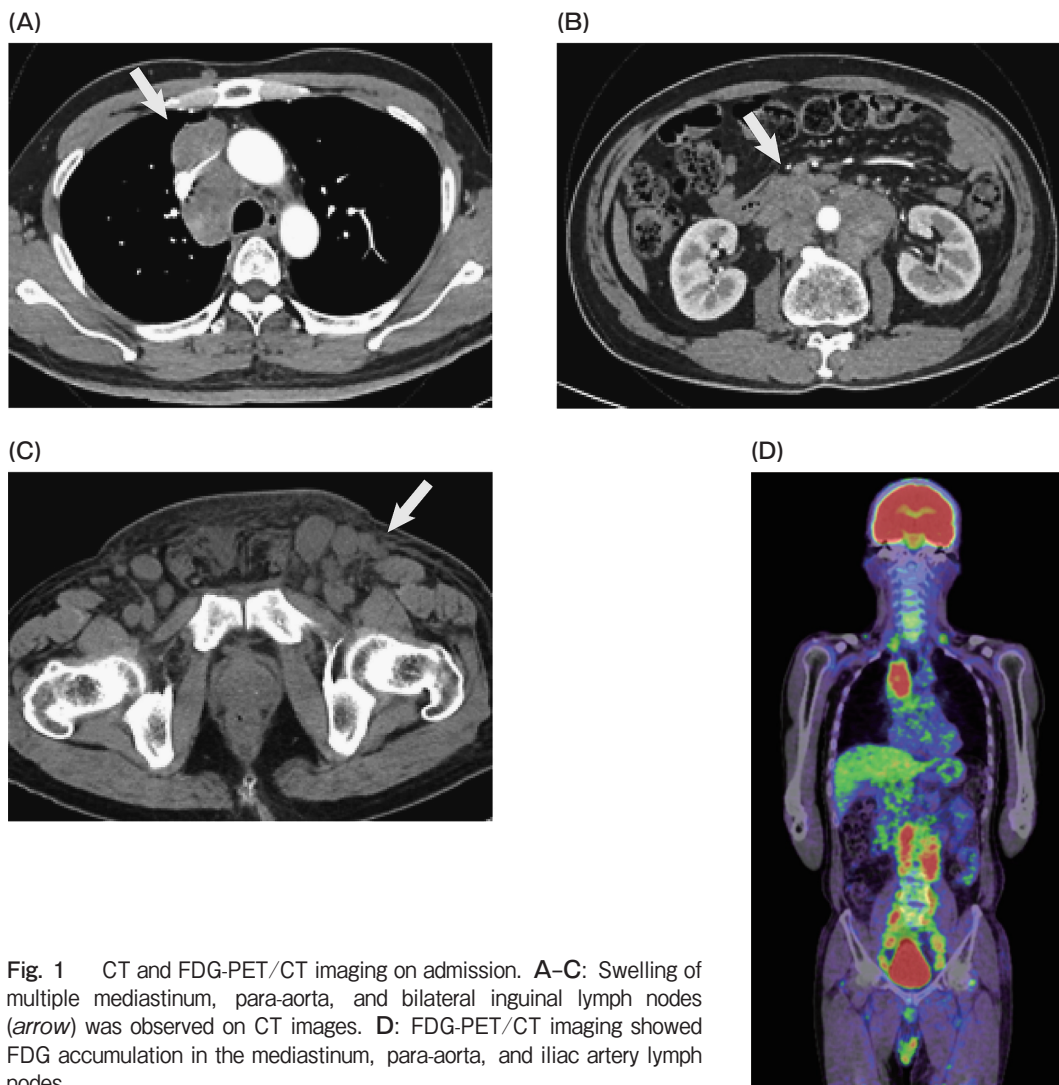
CT and FDG-PET/CT imaging on admission. A–C: Swelling of multiple mediastinum, para-aorta, and bilateral inguinal lymph nodes (arrow) was observed on CT images. D: FDG-PET/CT imaging showed FDG accumulation in the mediastinum, para-aorta, and iliac artery lymph nodes.
